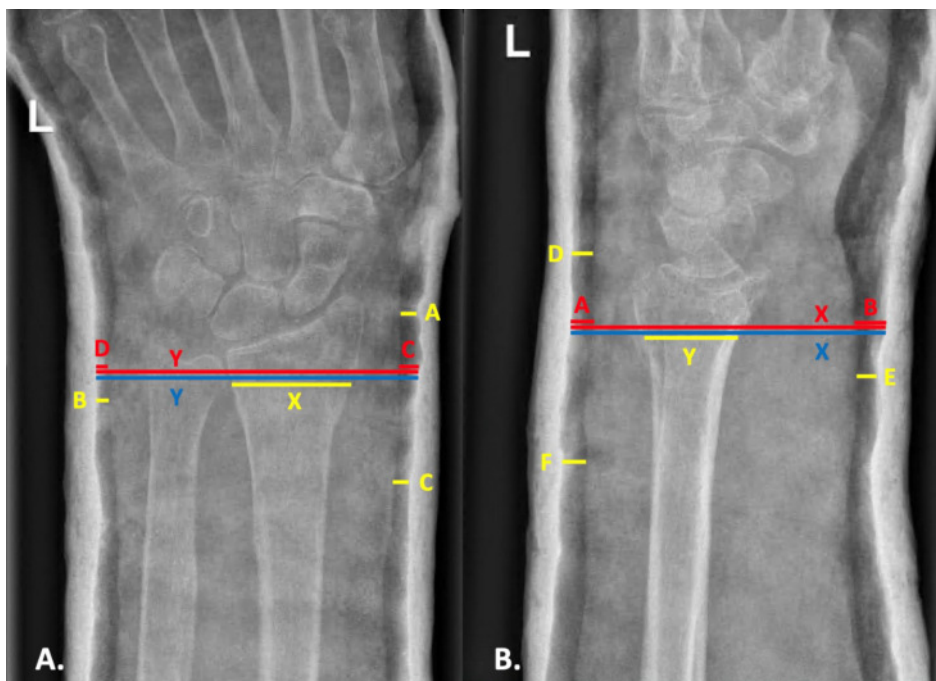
Cast indices measurements shown on postero-anterior (A) and lateral (B) radiographs.
